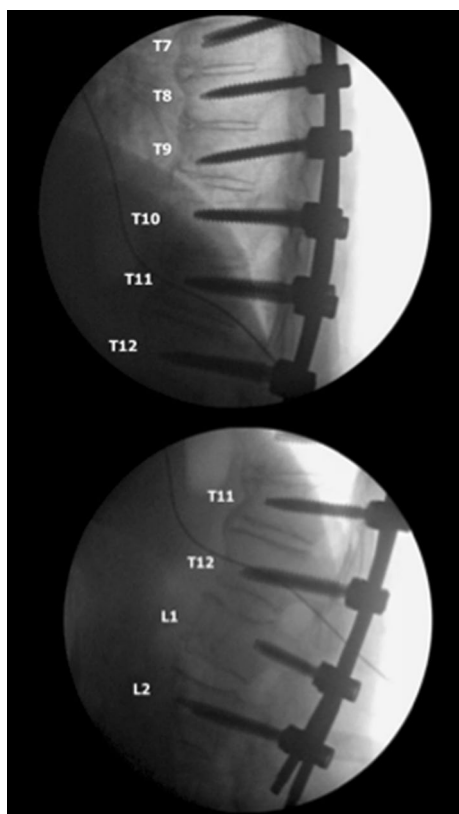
Intraoperative lateral X-rays of T7-L2 PSIF showing the spinal fusion hardware in place and near-anatomic positioning of the spine
